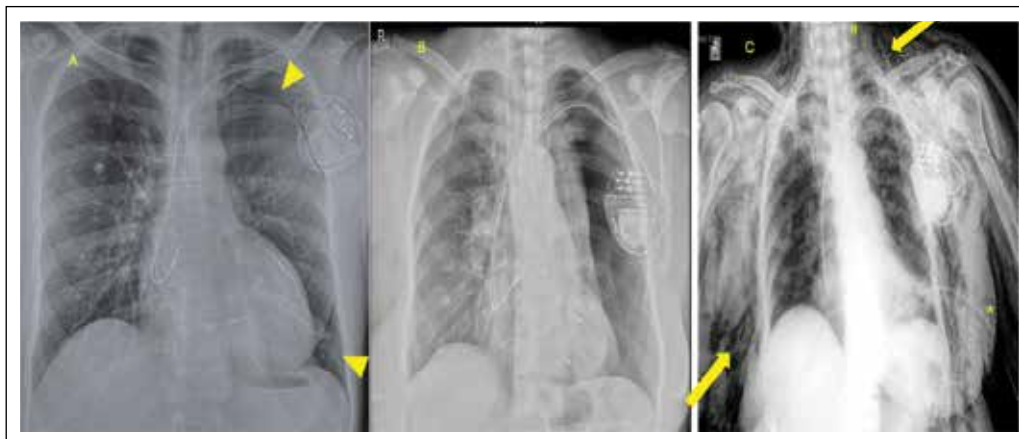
Frontal chest radiograph of three patients who underwent CRT showing the severity of pneumothorax. It can be as minimal as in the case of patient A, where pneumothorax was confined to the apex of the left lung and base without any mediastinal shift (arrowhead). This patient received conservative therapy, and the pneumothorax spontaneously cleared. Patient B, who underwent LOT-CRT, which showed massive left pneumothorax and was later intercostal tube drainage, was inserted and later stabilised and discharged (A); another patient who underwent CRT-P, post-procedure frontal chest radiograph showing extensive subcutaneous emphysema (arrow) and pneumothorax, note an intercostal tube drain insitu (*) for draining left tension pneumothorax. The pneumothorax may be asymptomatic in most cases as the compensatory hyperexpansion of other lungs ensures ventilation.
